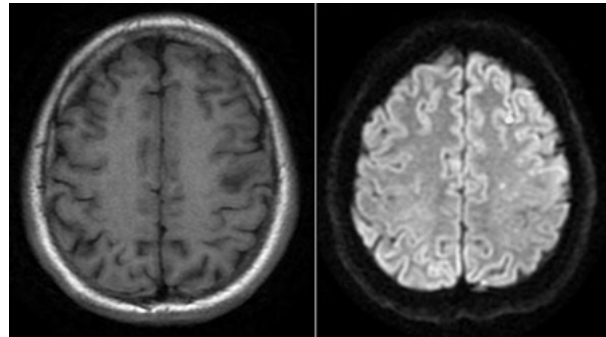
A. MRI FLAIR-weighted imaging without restriction in diffusion-weighted (DW) sequence showed a subacute/chronic ischemic lesion on left precentral gyrus. B. In DW images, multiple hyperintense punctate foci with decrement on apparent diffusion coefficient
